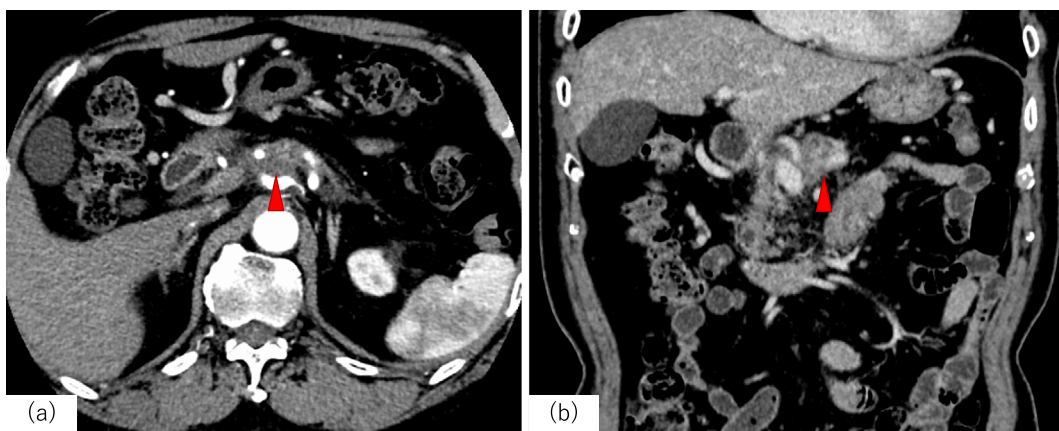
Computed tomography 6 months after the start of GnP. (a, b) pancreatic cancer (red arrowhead). GnP: gemcitabine+nab-paclitaxel
